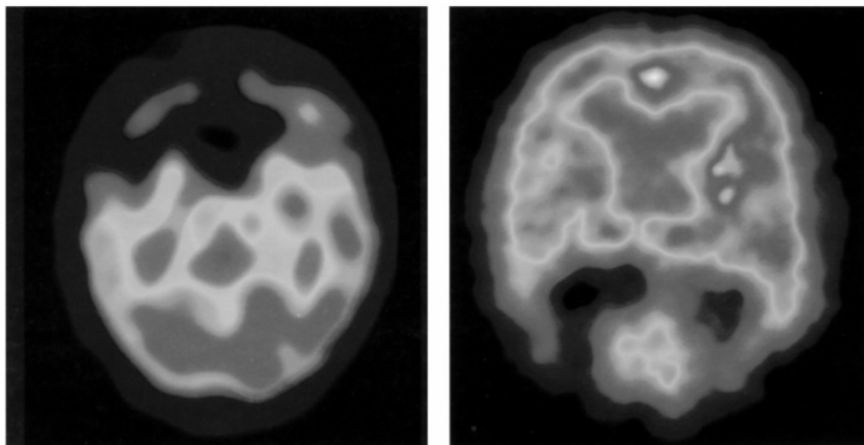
Comparison between HMPAO SPECT profiles of a patient with fronto-temporal dementia (on the left) and a patient with AD (on the right)
